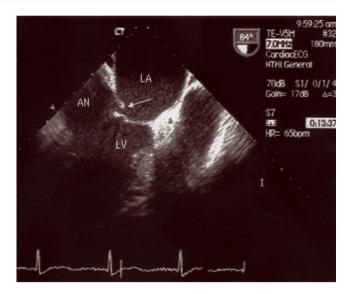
Transesophageal echo showing rupture of commissural chordae of the posterior mitral leaflet.
